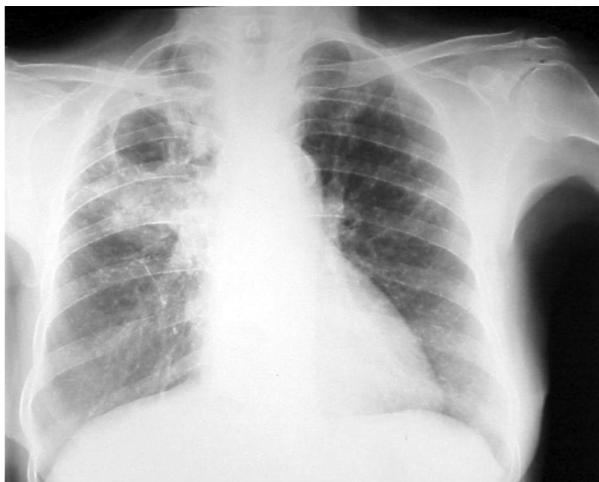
Chest radiography in patient 3 reveals a thick-walled cavity along with micronodular patterns in the right upper lobe.
